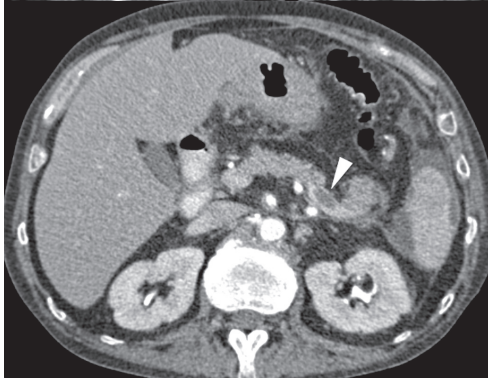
A 56-year-old man with thrombus in the splenic vein. Contrast-enhanced CT depicts an intraluminal filling defect in the splenic vein (arrowhead), compatible with a thrombus. Usually, this is not an indication for initiation of anticoagulant therapy.
